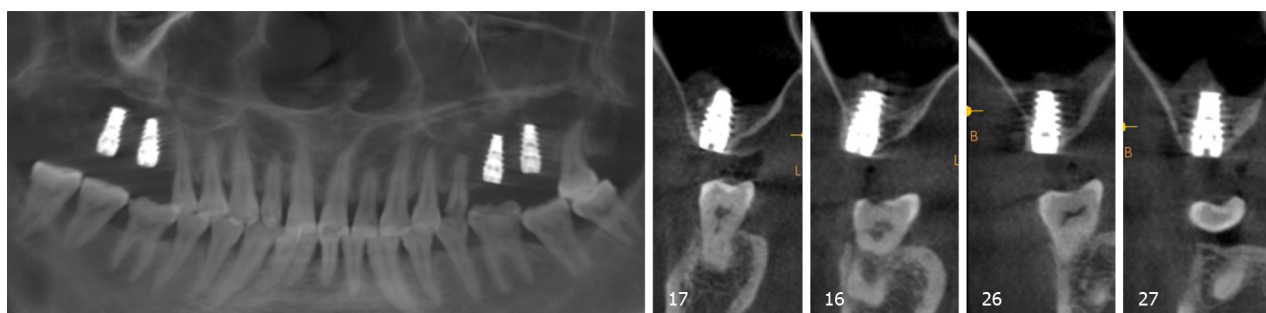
Cone-beam computed tomography after the first-stage surgery.
